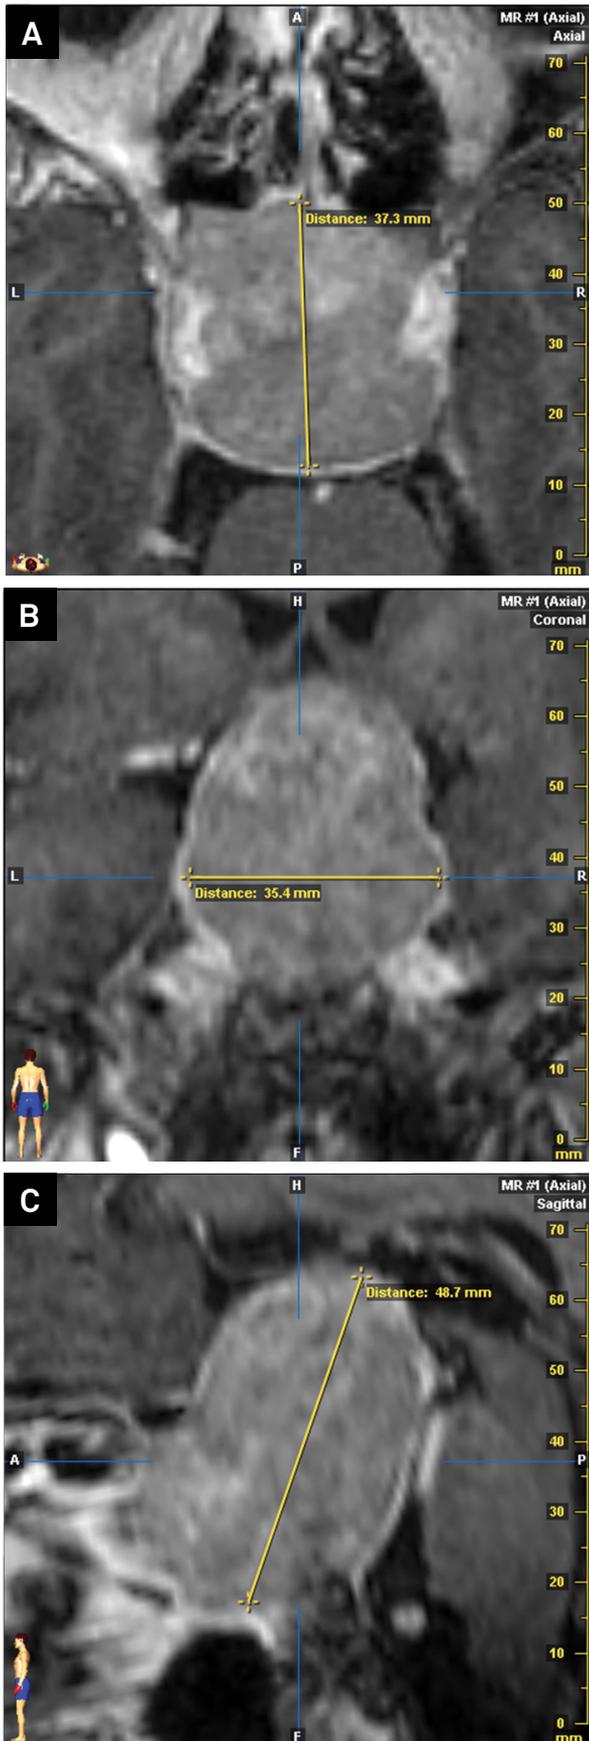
T1-weighted gadolinium enhanced MRI of the sellar and parasellar regions in a patient with pituitary adenoma. (A) anteroposterior, (B) latero-lateral and (C) craniocaudal measurements of the tumor.
